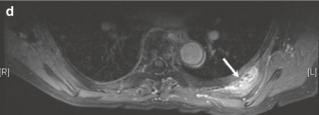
Elastofibroma dorsi in two patients. Patient 1. (a) Axial CT shows an ill-defined soft tissue on the right side at characteristic location (arrows). Patient 2. (b–d) Axial T1W, T2W, and postcontrast T1W images show typical features of elastofibroma (arrow) on the left side
